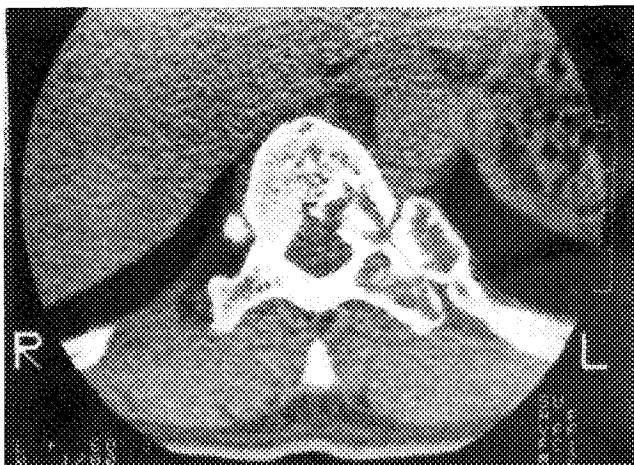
Computed tomographic scan. High-density borderline between the normal vertebral body and the lesion was shown.
